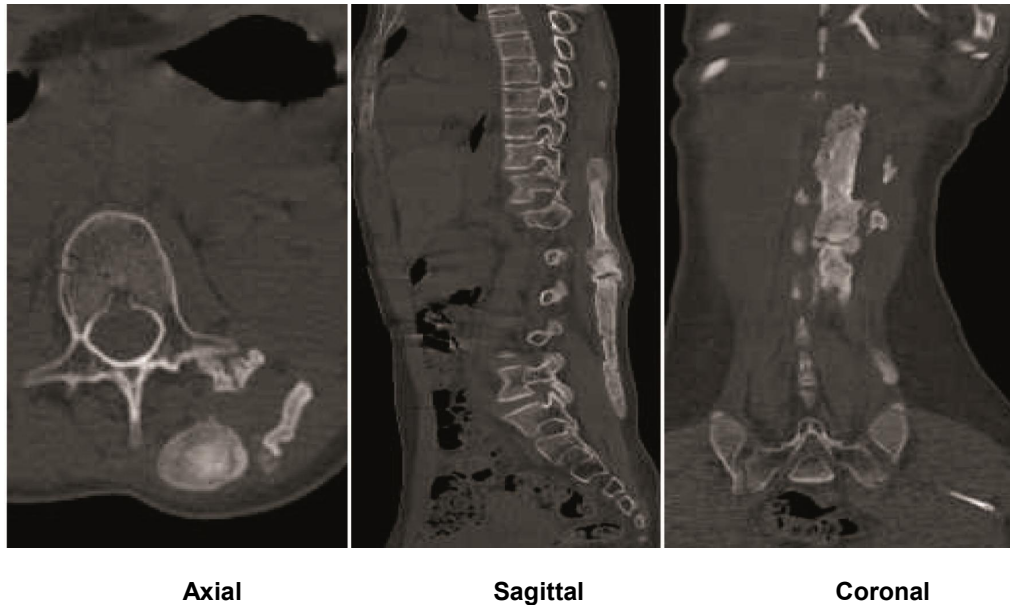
CT- Scan Indicates bony mass in paravertebral muscles
